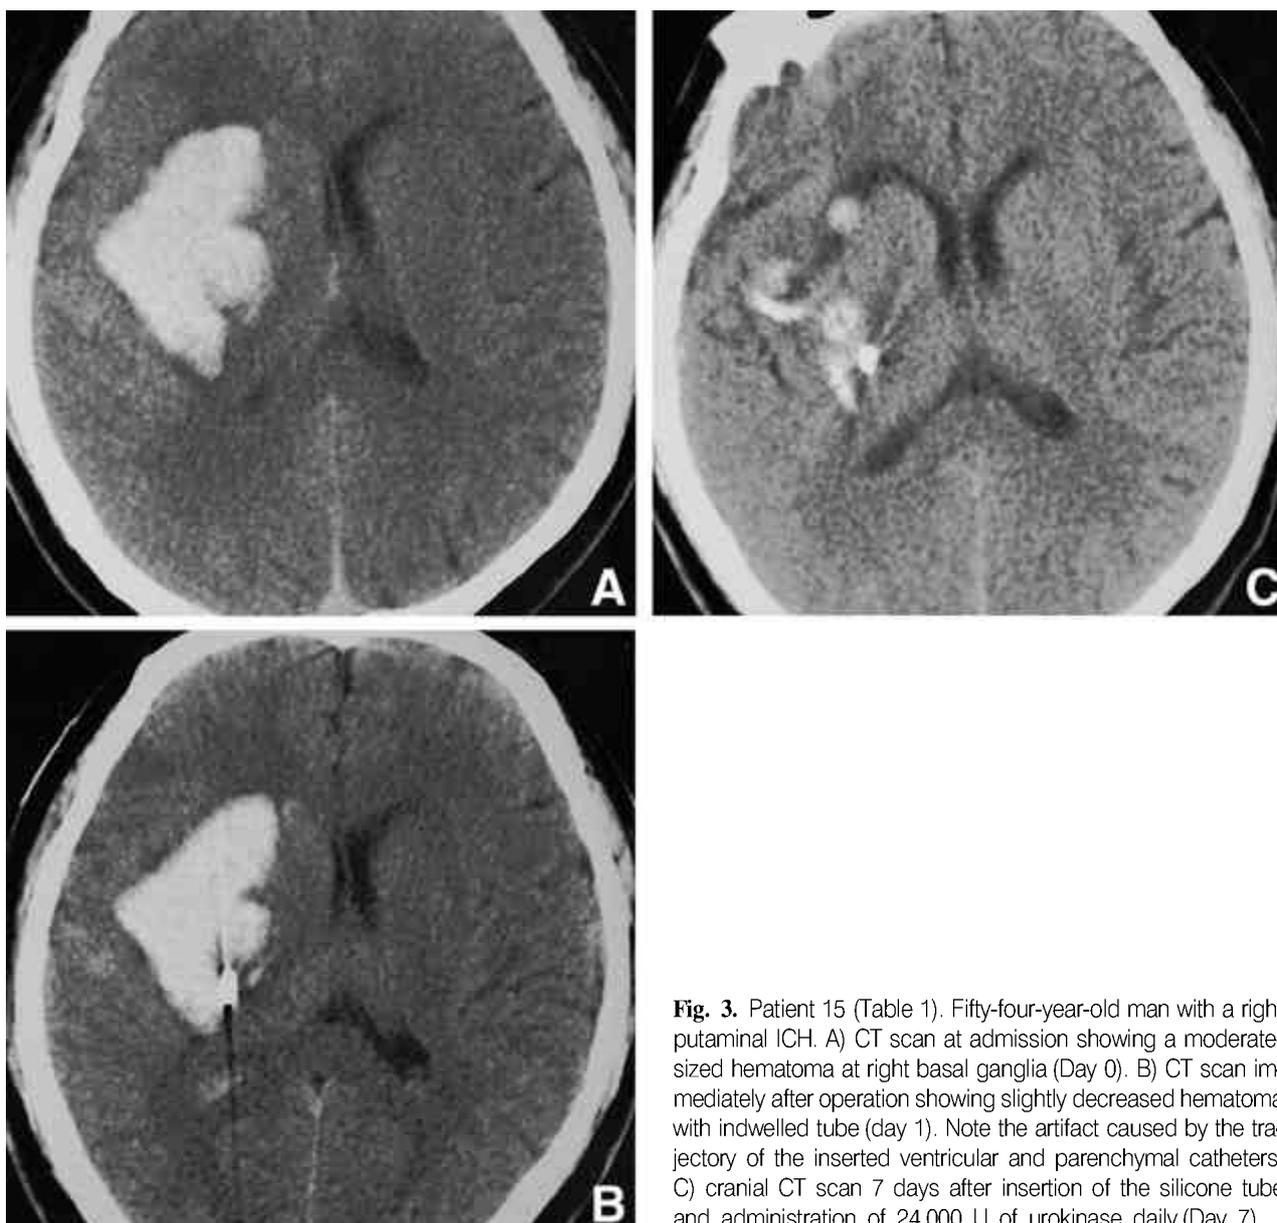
Patient 15 (Table 1). Fifty-four-year-old man with a right putaminal ICH. A) CT scan at admission showing a moderate-sized hematoma at right basal ganglia (Day 0). B) CT scan immediately after operation showing slightly decreased hematoma with indwelled tube (day 1). Note the artifact caused by the trajectory of the inserted ventricular and parenchymal catheters. C) cranial CT scan 7 days after insertion of the silicone tube and administration of 24,000 U of urokinase daily (Day 7).
